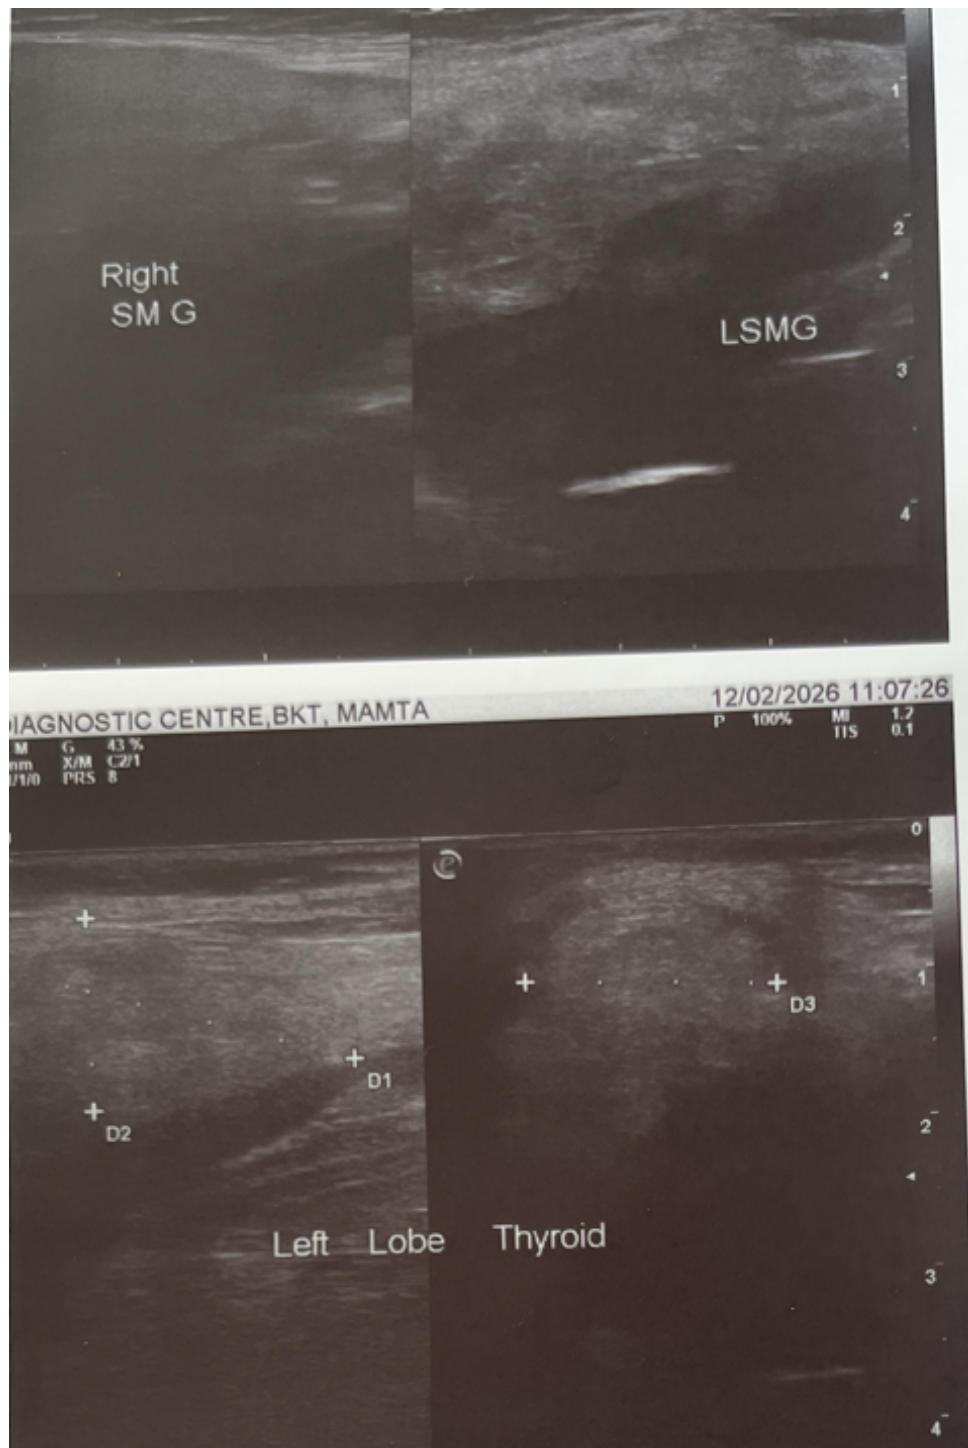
Figure 1B: High-Resolution Ultrasound of the Left Lobe showing normal echotexture and absence of nodules, ruling out structural malignancy.
